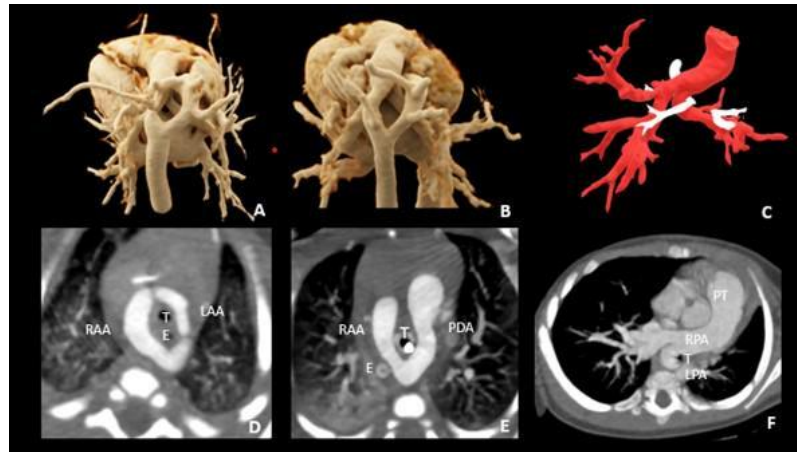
Cardiac CT in different vascular rings. A and D show double aortic arch. B and E represents right aortic arch with left patent ductus. C and F show pulmonary sling. RAA: right aortic arch, LAA: left aortic arch, PDA patent ductus arteriosus. PT: pulmonary trunk, RPA: right pulmonary artery, LPA: left pulmonary artery. T: trachea. E: esofagus.
